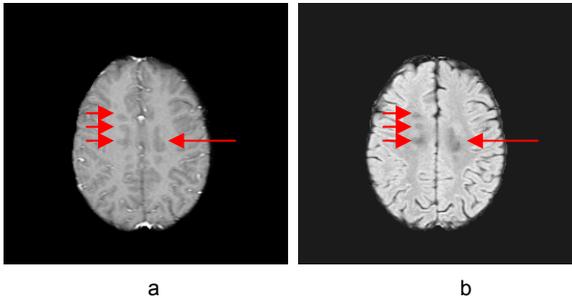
a) T1-weighted image with b) the corresponding *pseudoT1* image produced from the subtraction of the late echo from the early echo in a conventional FSE dual-echo acquisition. Red arrows indicate the presence of MS lesions
